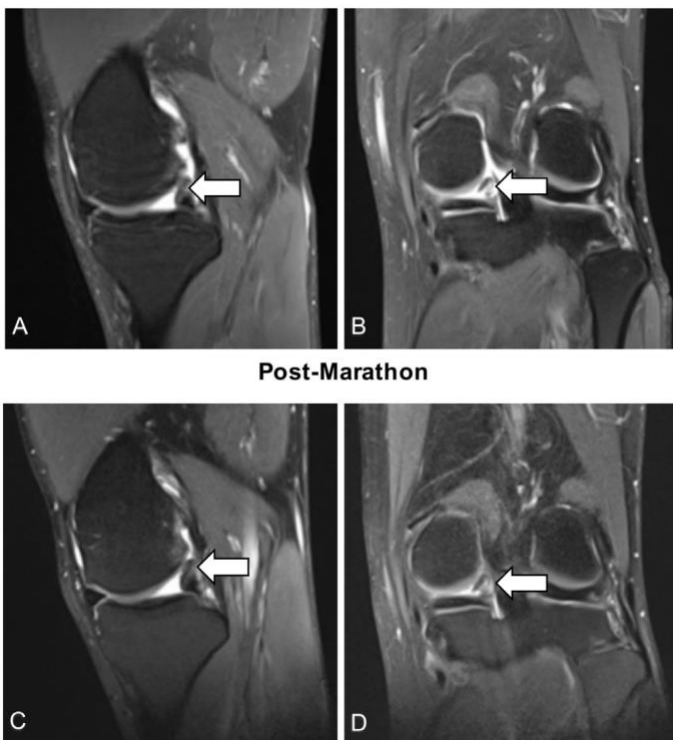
from Horga et al. [83] MRI scans of a 45 year old marathon runner with finishing time 3 hours and 51 min who was diagnosed during the pretraining period with bucket-handle tear of the posterior horn of the medial meniscus as it is indicated by (A) the sagittal PD FS image ( $TR=4670$ ,  $TE=41$ , slice thickness: 3 mm) (white arrow) and the (B) coronal PD FS image ( $TR=5240$ ,  $TE=41$ , slice thickness: 3 mm) where the meniscal flap within the intercondylar notch (arrow) is shown. The status of the meniscal tear did not change in 2 weeks after the marathon (see C, (D)). PD FS, proton density-weighted fat suppressed; TR, repetition time; TE, echo time.
